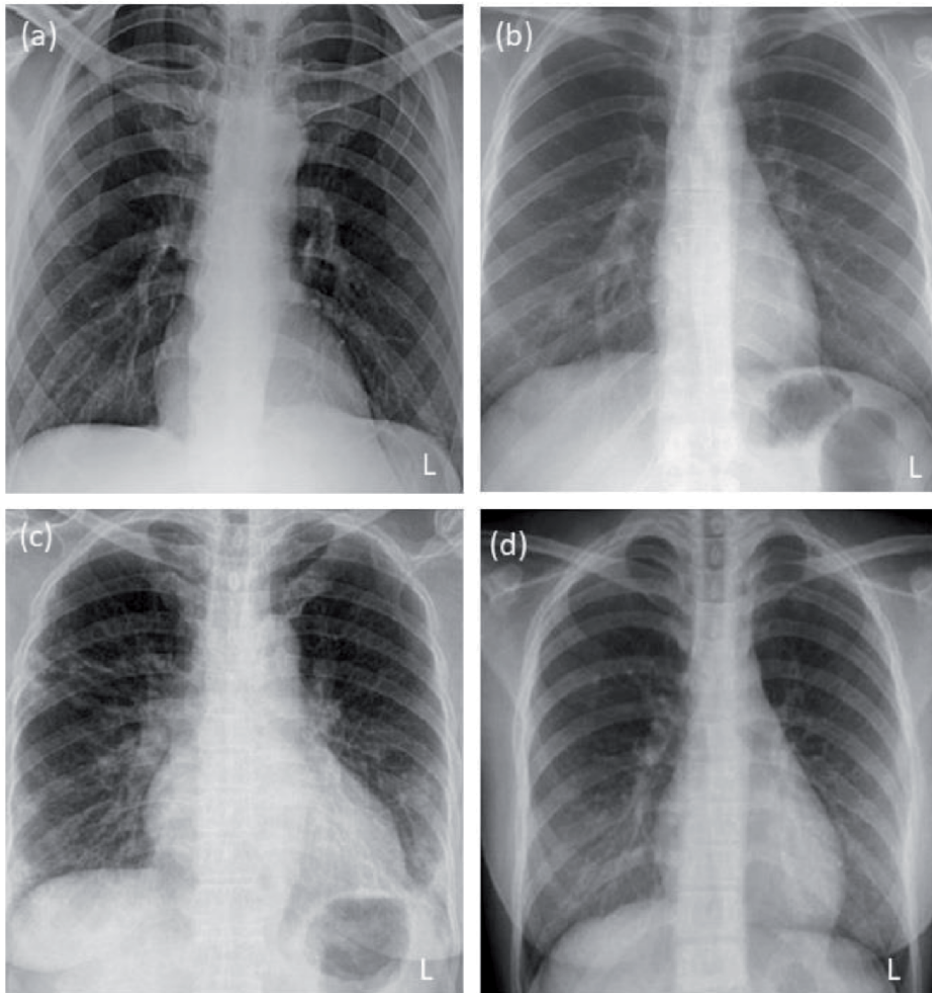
Comparative chest X-ray findings in (a) normal CXR (b) SARS (c) MERS (d) COVID-19. [source: Images adapted from Pereira et al. [30]].
